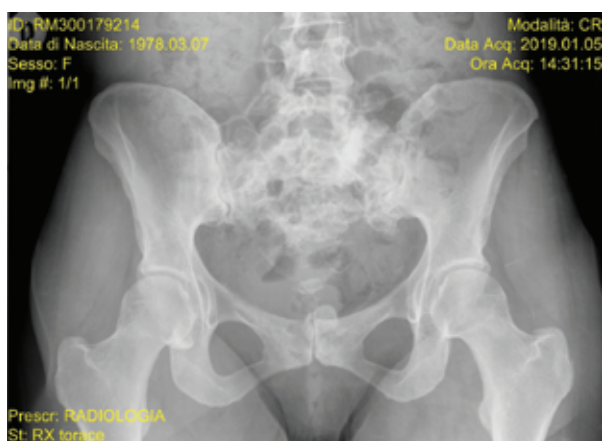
Plain Radiograph of the hip that demonstrate a lytic lesion of the sacrum.
